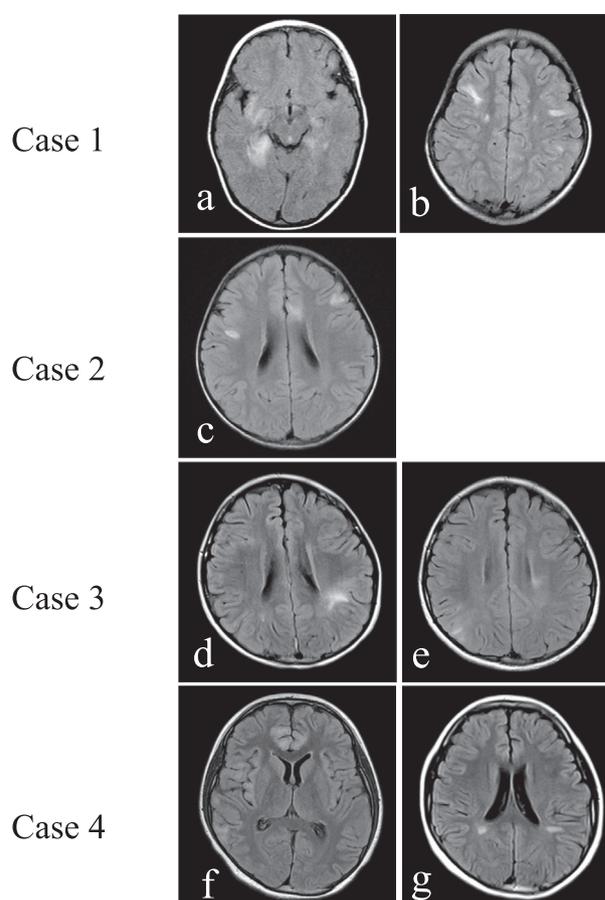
Brain MRI findings. All are T2 FLAIR images. a) First episode of Case 1 with optic neuritis. A large (>2 cm) poorly demarcated lesions in the right temporal white matter and disseminated lesions in the bilateral subcortical region to deep white matter were detected. (b) New brain lesions without clinical symptoms in Case 1. Disseminated poorly demarcated lesions were detected in the parietal subcortical white matter. (c) Second episode of Case 2 with transverse myelitis. Well-demarcated lesions were detected in the bilateral frontal to temporal subcortical white matter. (d) First episode of Case 3 with transverse myelitis. Poorly demarcated lesions were detected in the left temporal white matter. (e) Second episode of Case 3 with headache. Faint disseminated lesions were newly detected in the parietal cortex to subcortical white matter. (f) First episode of Case 4 with optic neuritis and psychiatric symptoms. Poorly demarcated lesions were detected in the bilateral cortex to subcortical white matter. (g) New brain lesions without clinical symptoms in Case 4. Well-demarcated lesions were detected in the bilateral white matter.
